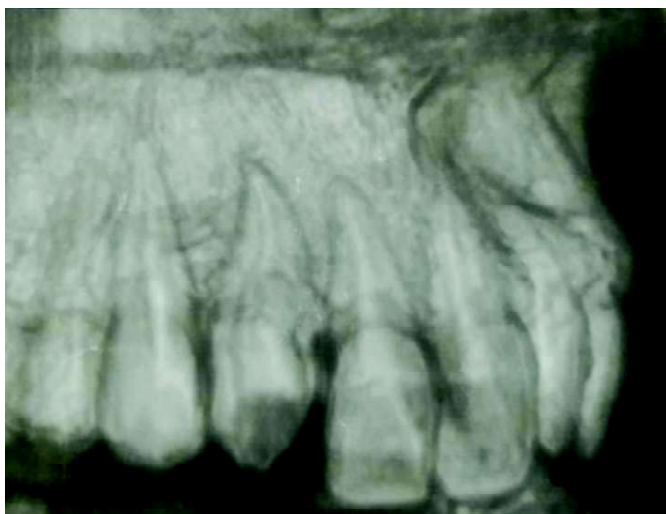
Pre-operative CBCT Image
